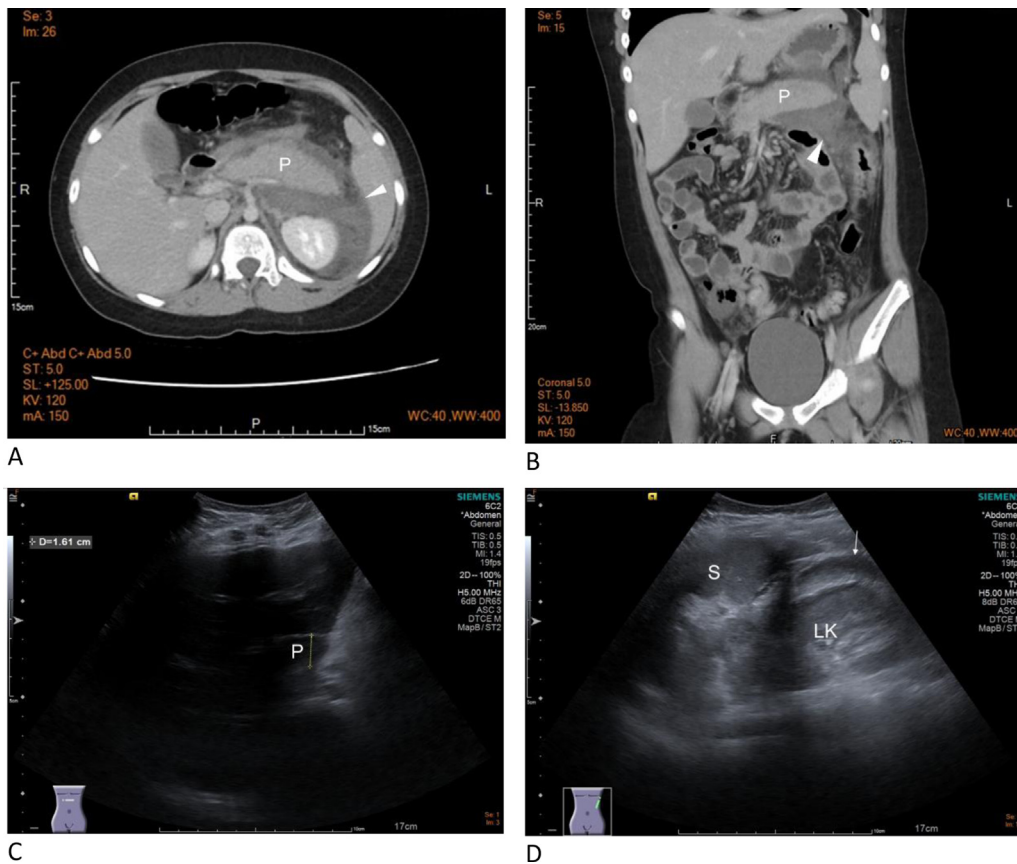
Contrast enhanced computed tomographic (CECT) and ultrasonography (USG) of abdomen done on the day of admission. (A) Horizontal and (B) coronal section showed that the pancreas was edematous with peripancreatic fluid collections (arrowheads). (C) Swelling and blurred margin of the pancreatic body, 1.6 cm in diameter. (D) Hypochoic area with heterogeneous content between the spleen and the left kidney, indicating pyoascites at splenorenal recess (arrow). LK = left kidney; P = pancreas; S = spleen.
